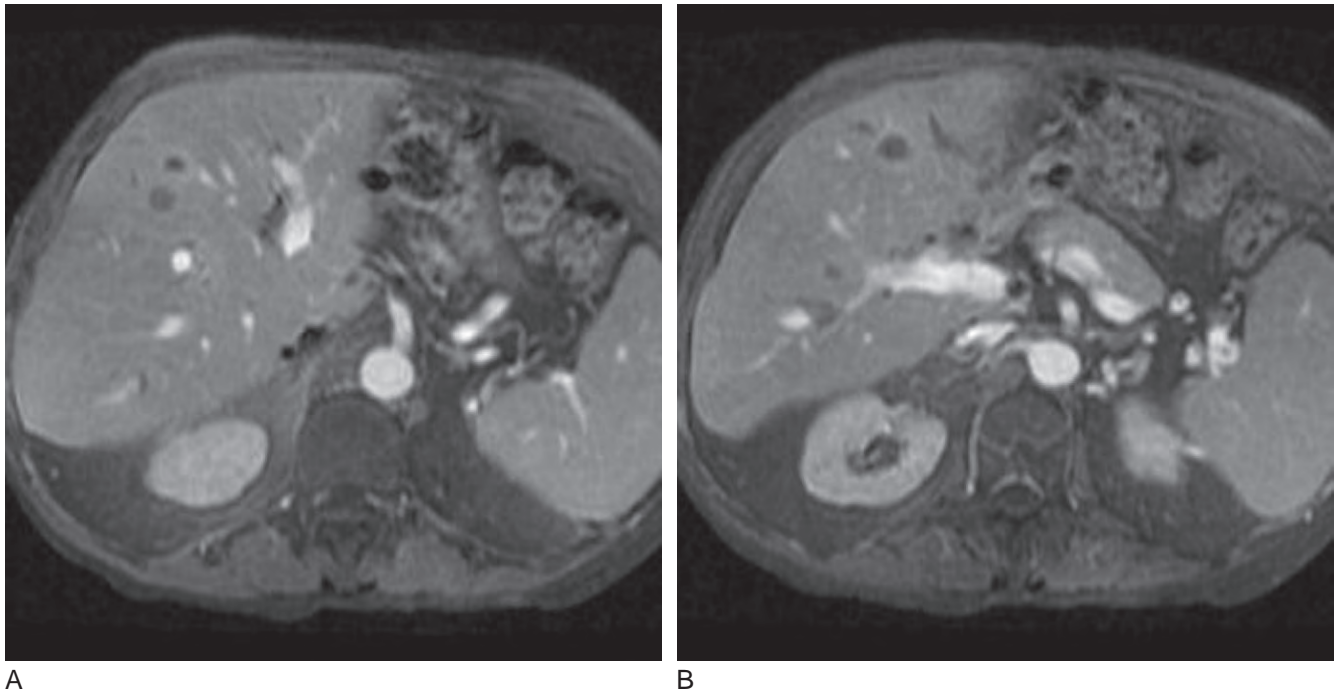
A and B, Gadolinium-enhanced T1-weighted MR imaging through the liver reveals multiple low-signal lesions with a thin peripheral ring of enhancement in this patient with multiple pyogenic microabscesses.
